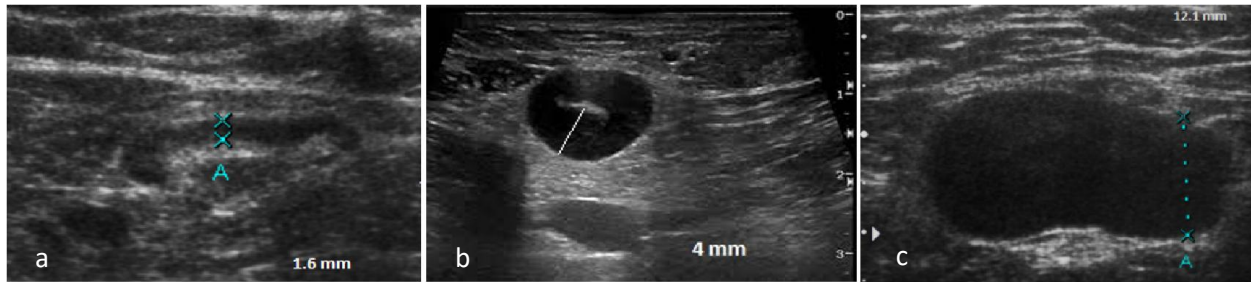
Sonographic features of axillary lymph nodes; a) benign lymph nodes with oval/elongated shape, ≤ 3 mm cortical thickness and preserved fatty hilum. (b & c) suspicious lymph nodes with circumscribed/enlarged sizes, > 3 mm cortical thickness and loss of fatty hilum
